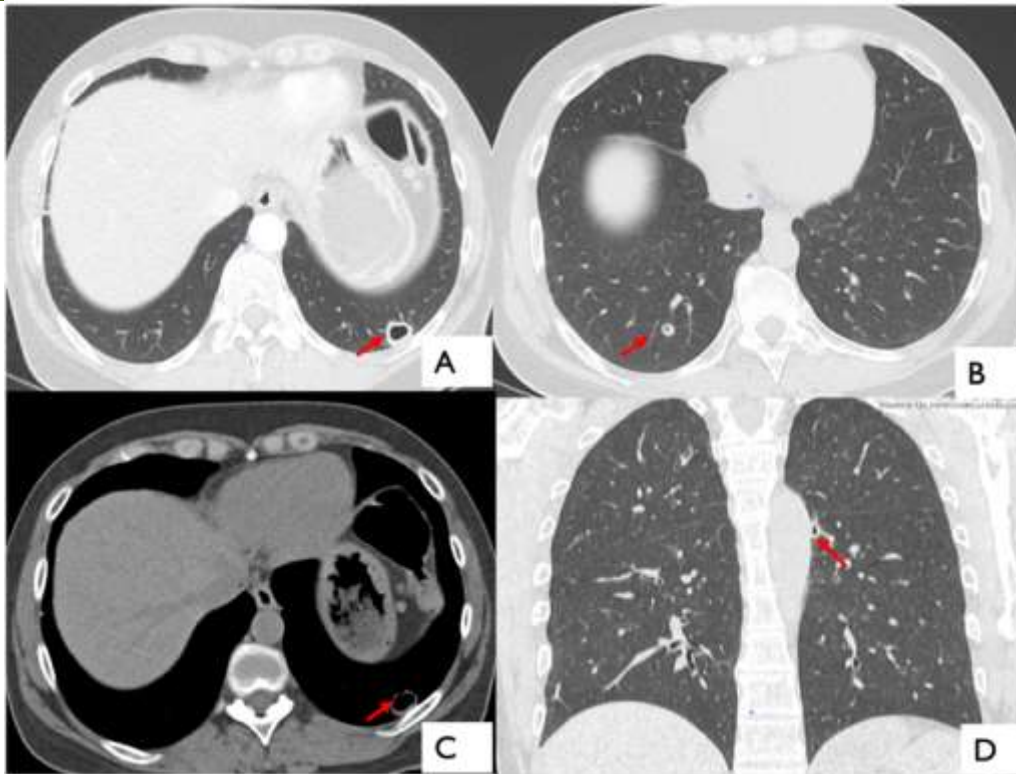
Axial and coronal CT lung and mediastinal windows showing multiples cavitary nodules with focally thickened walls (red arrows)
